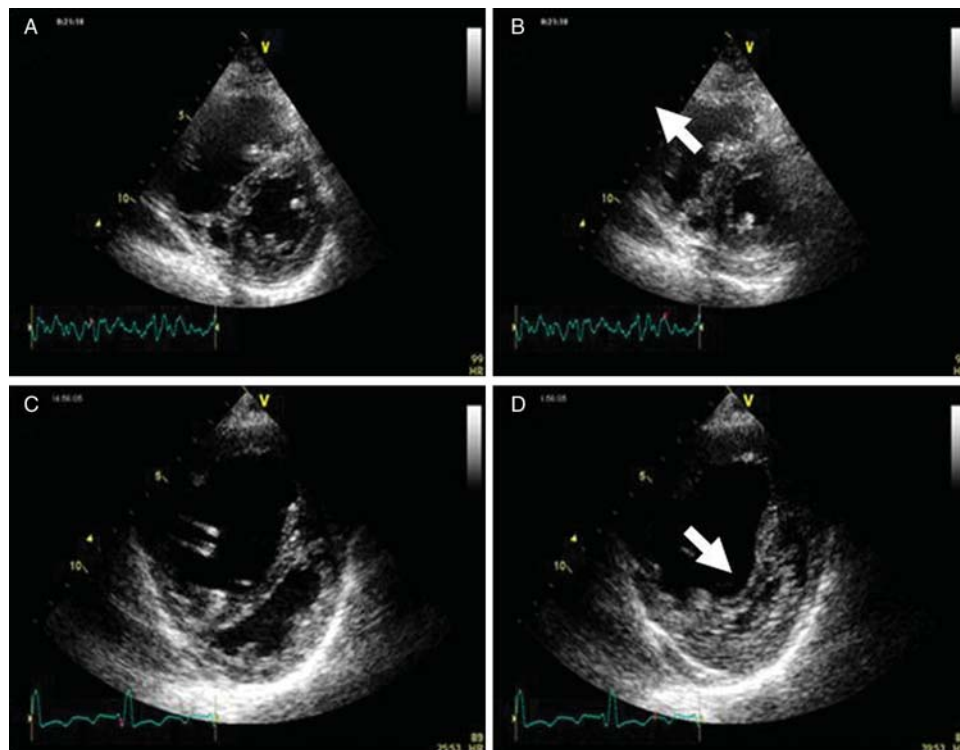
Parasternal short-axis views at the mid-ventricular level. (A and B) Patient with atrial septal defect type ostium secundum, consequent right ventricular volume overload, and mildly elevated pulmonary artery pressures—flattening of the interventricular septum at end diastole (A) and recovering of shape at end systole (arrow) (B). (C and D) Patient with severe pulmonary arterial hypertension and consequent severe right ventricular pressure overload—flattening of the interventricular septum both at end diastole (C) and end systole (arrow) (D).
